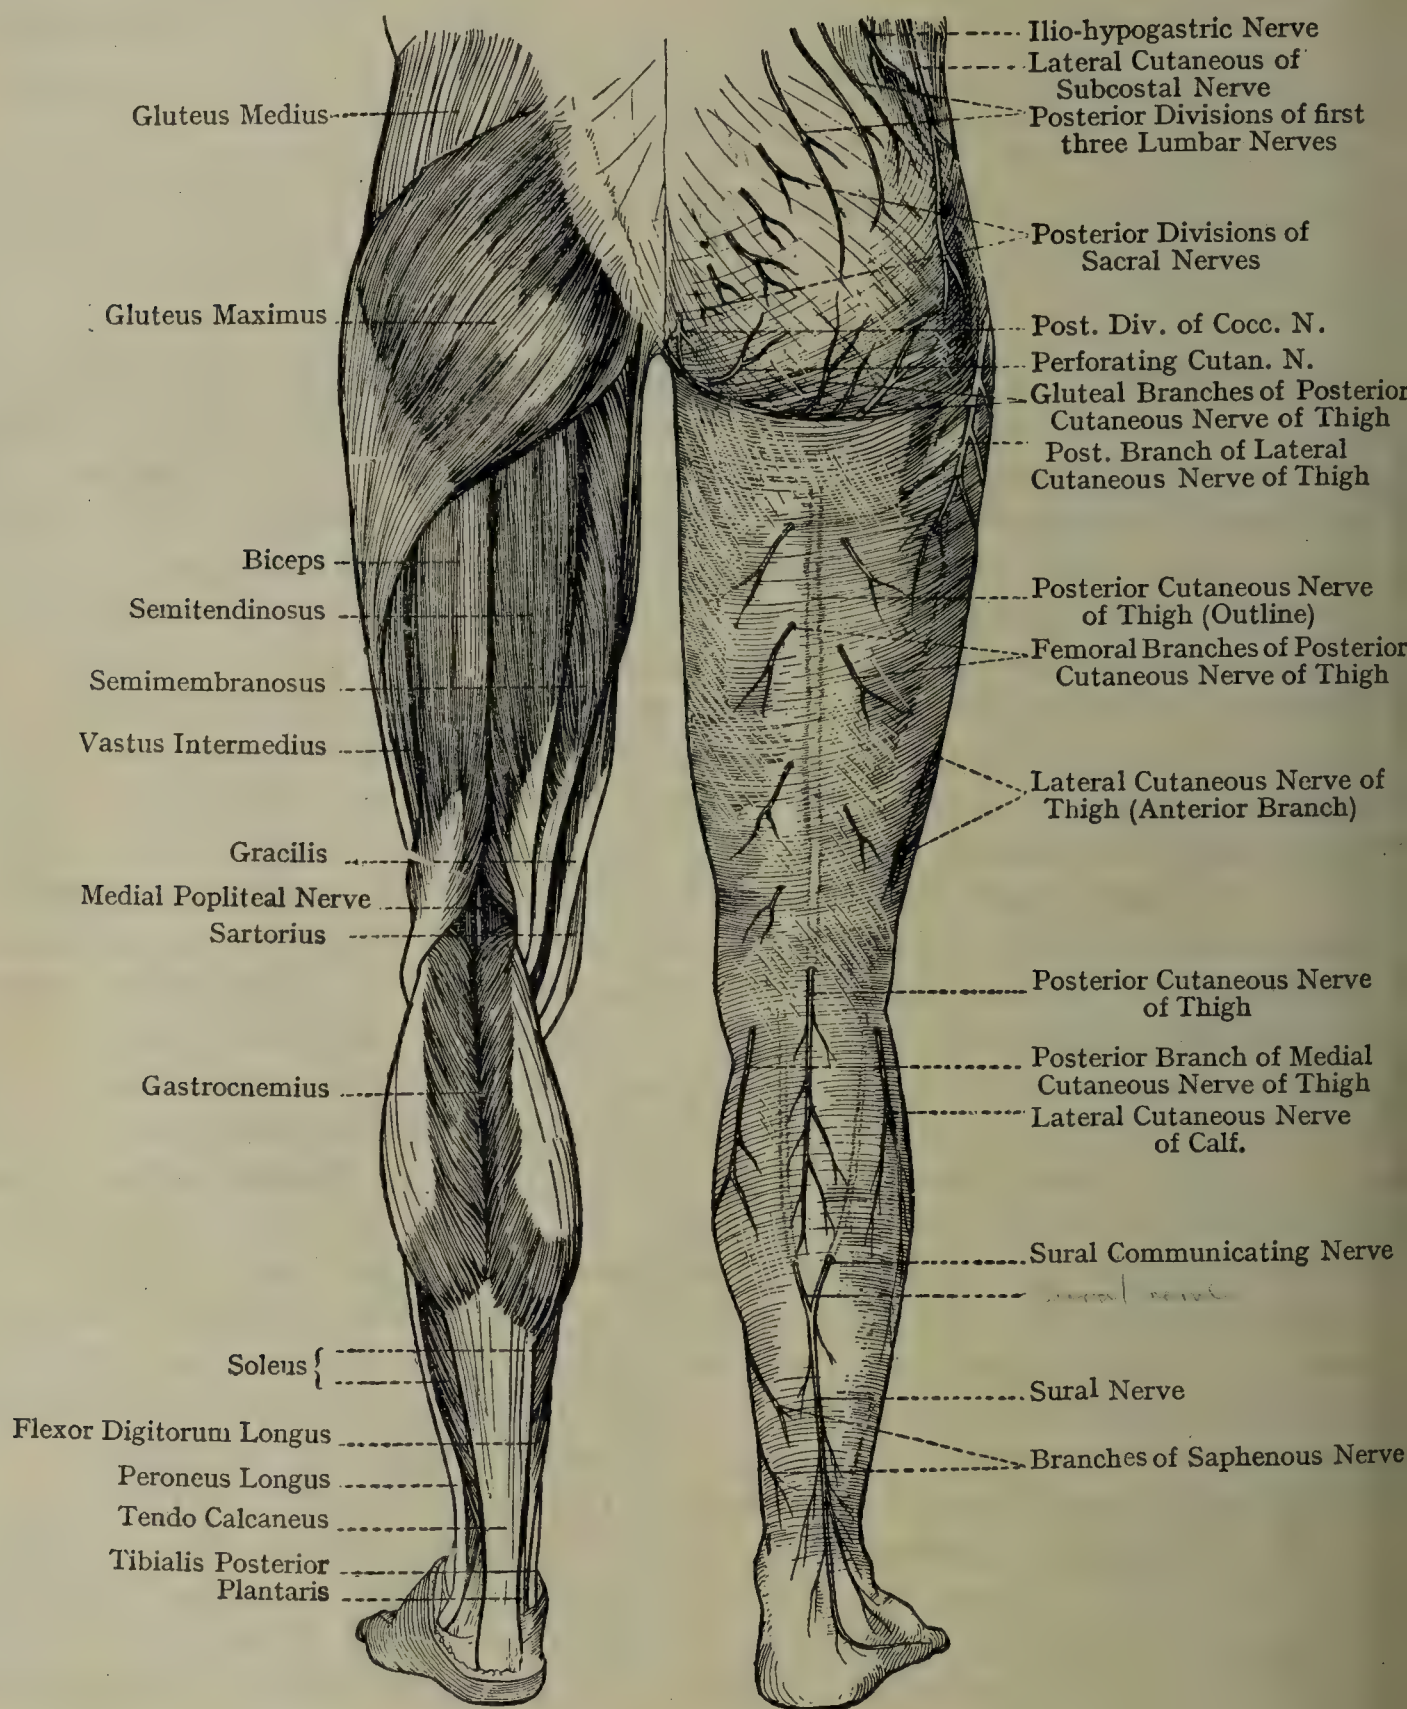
MUSCLES AND CUTANEOUS NERVES OF THE LOWER LIMB (POSTERIOR ASPECT).
